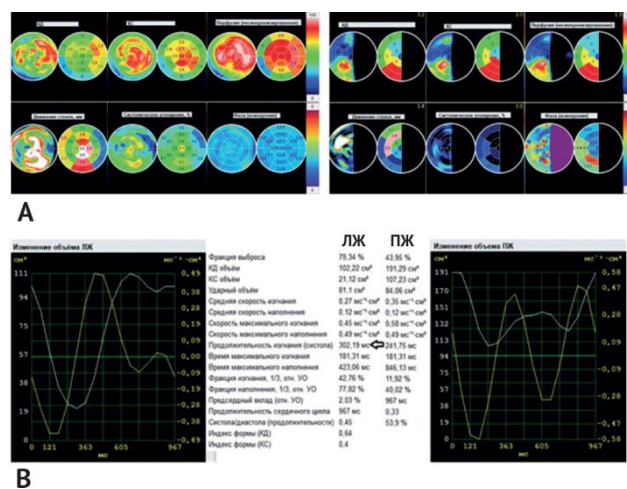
Results of single-photon emission computed tomography synchronized with echocardiography after placement of 2 stents in the anterior interventricular branch: A - bull's-eye with changes in perfusion, wall motion, and systolic thickening by segments; B - flow-volume curves with quantitative parameters of the function of the left and right ventricles
